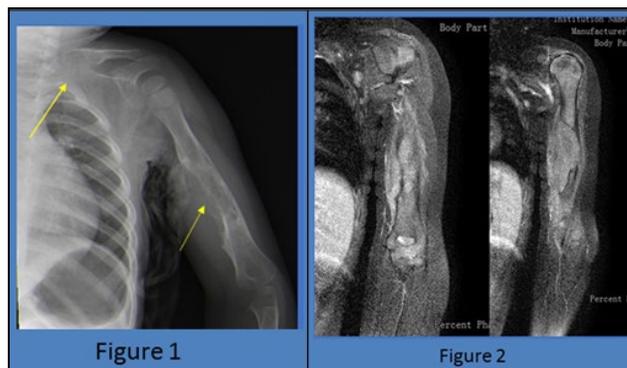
Plain radiograph images of the left clavicle and left humerus with osteolytic lesion as shown by the yellow arrows. Figure 2: MRI images showing irregular expansile bony lesion occupying the diaphysis of the left humerus
